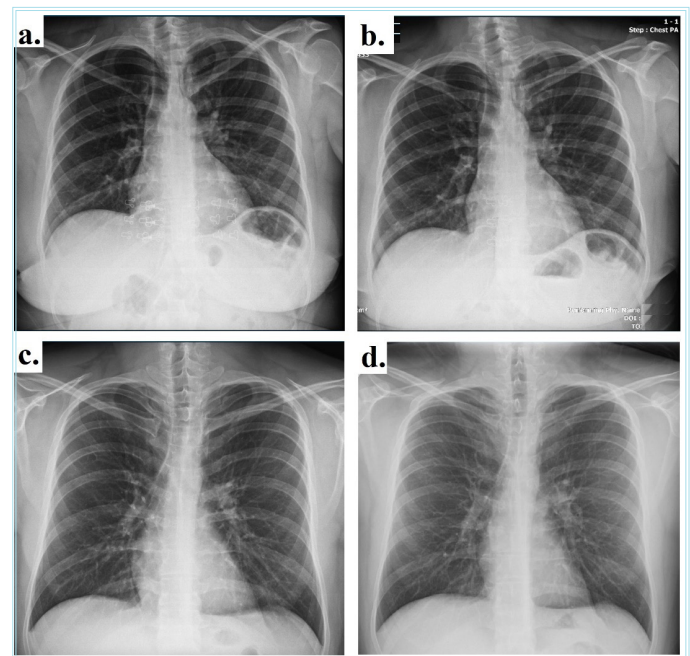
(a) Preoperative chest X-ray of a 54-year-old female patient. (b) Postoperative chest X-ray of the same patient. (c) Preoperative chest X-ray of a 27-year-old male patient. (d) Postoperative chest X-ray of the same patient
